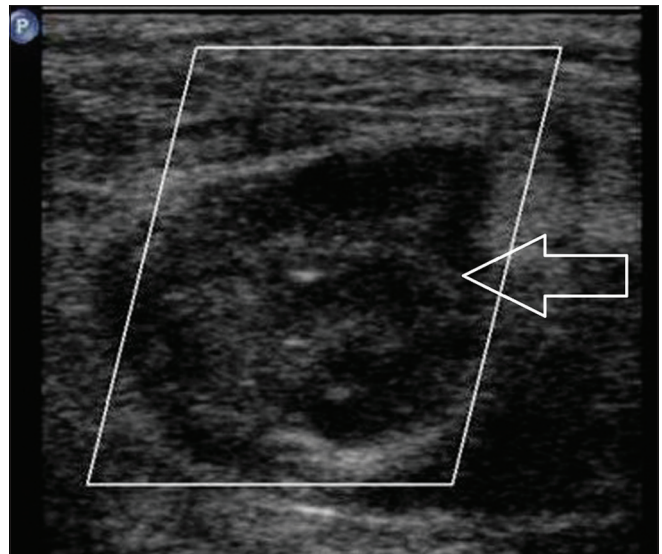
Satisfactory thrombosis (arrow) of the pseudoaneurysm at check ultrasound
